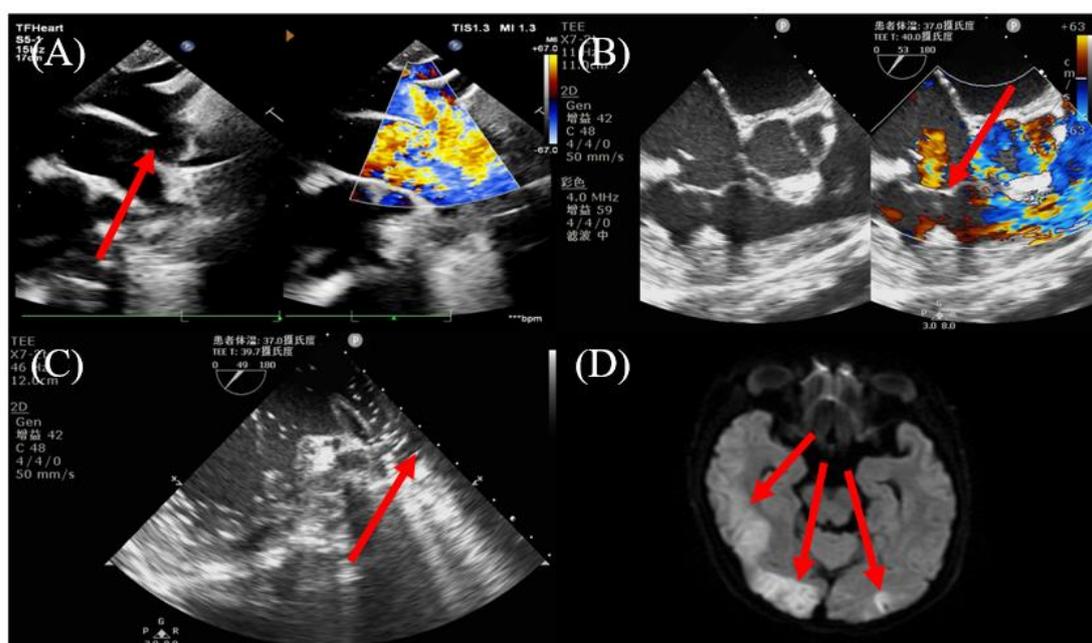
(A) Transthoracic echocardiography showing patent ductus arteriosus (red arrow). (B) Transesophageal echocardiography showing moderate regurgitation tricuspid valve after first postoperative (red arrow). (C) Transesophageal echocardiography shows a large amount of gas coming out of the pulmonary veins (red arrow). (D) Postoperative magnetic resonance imaging of the head image showing several cerebral infarct area (red arrow).
